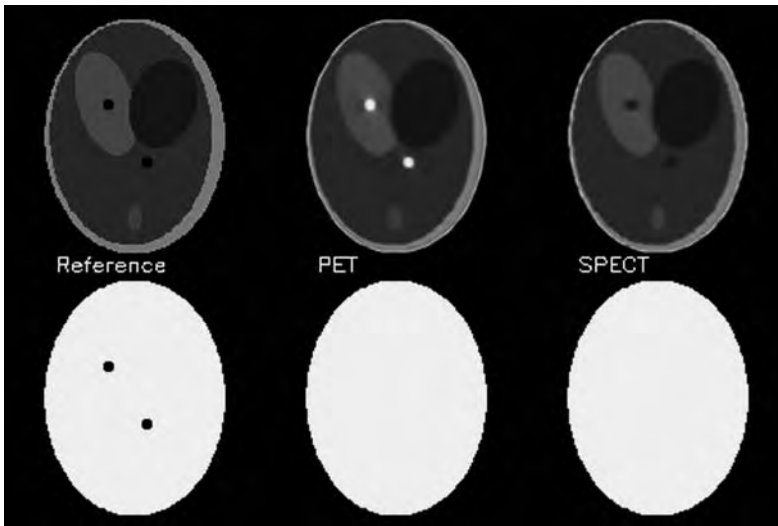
Reconstruction artefact due to a region of zero attenuation and activity, which was missed in the transmission map: *Top*, reference image (*left*), reconstruction from PET (*centre*) and SPECT (*right*) projections. *Bottom*, the true attenuation map (*left*), and the maps used for attenuation correction in PET (*centre*) and SPECT (*right*) reconstruction
